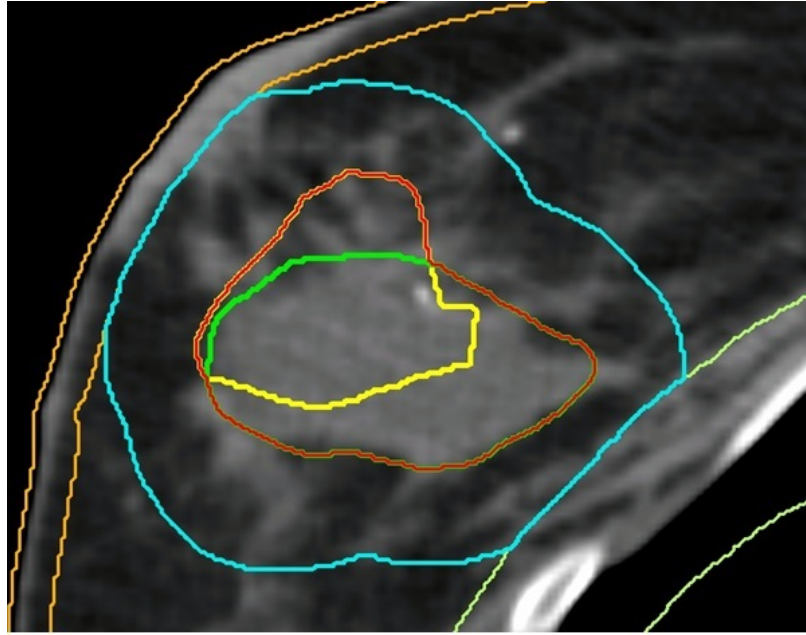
The total volume encompassed by  $CTV_{CT}$  (green) and  $CTV_{US}$  (yellow) is used to define  $CTV_{CT+US}$  (red) and resulting  $PTV_{CT+US}$  (blue).
